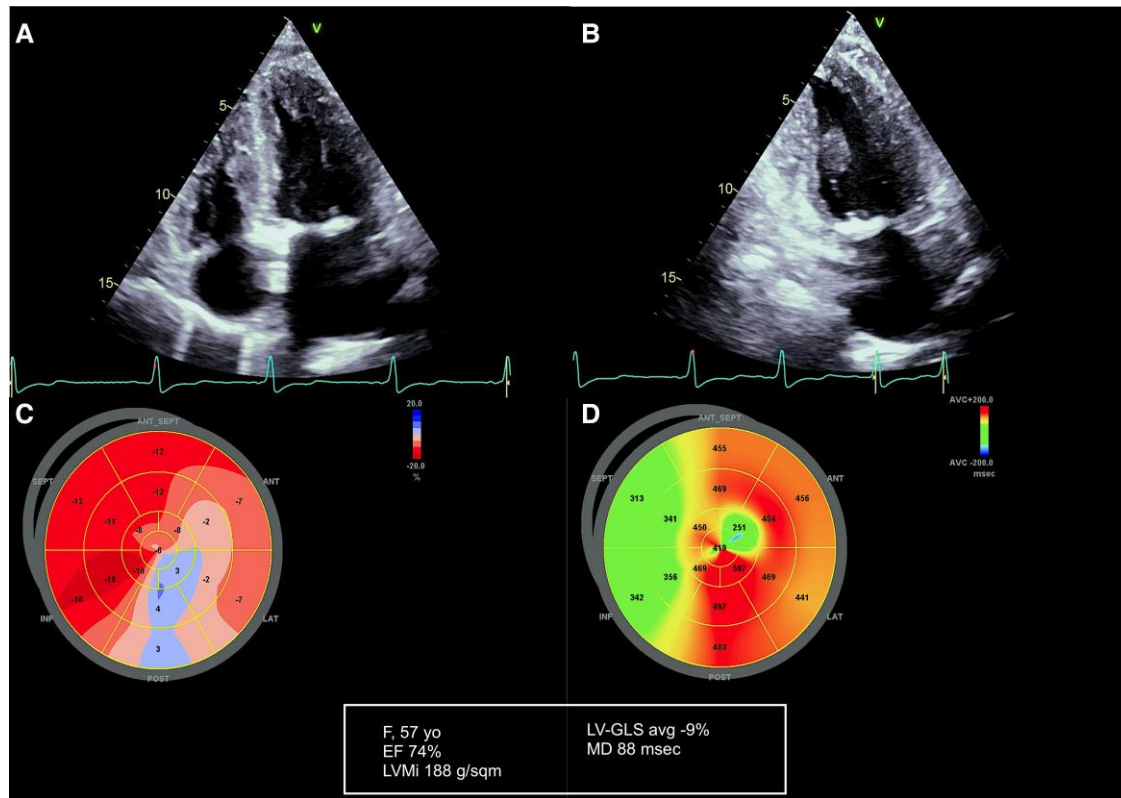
Patient with AFD–LVH. (A) Apical four-chamber view; (B) apical two-chamber view; (C) global longitudinal strain; (D) mechanical dispersion.
